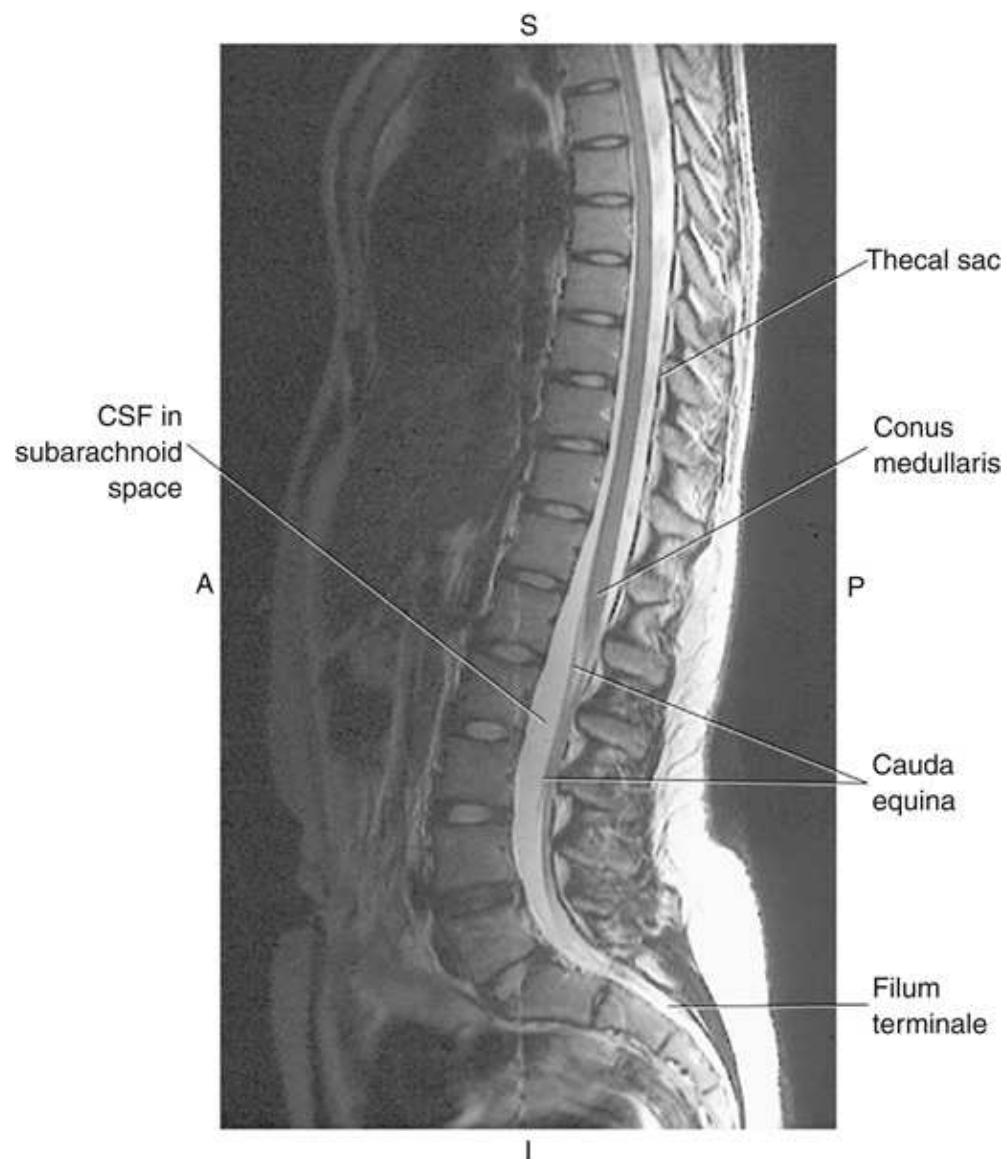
Mid-sagittal T2-weighted magnetic resonance image demonstrating spinal cord within the vertebral canal, along with thecal sac and *cerebrospinal fluid* (CSF) flowing in the subarachnoid space.
